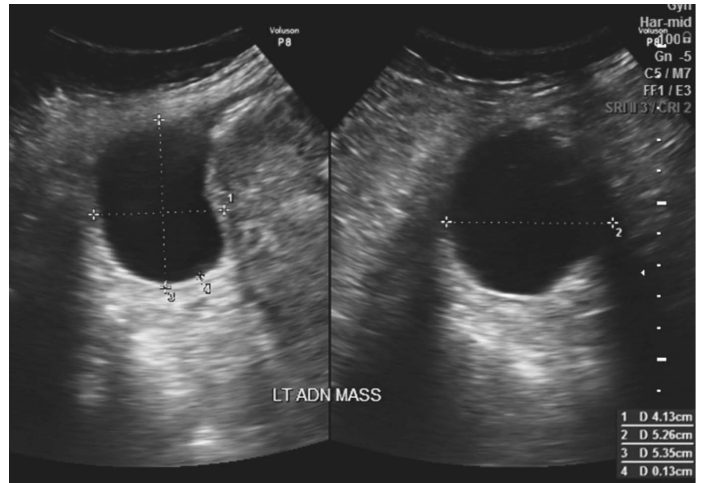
Transabdominal ultrasound of the left adnexal mass on anteroposterior (left) and transverse (right) views.
